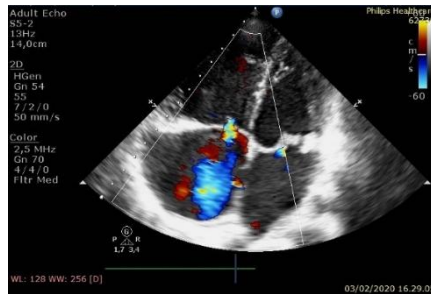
Echocardiography taken before (left side) and after (right side) PBMV. MVA planimetry was increased from 0.3 cm² (before PBMV) to 1.1 cm² (after PBMV). Tricuspid regurgitation was improved from severe (before PBMV) to mild - moderate (after PBMV).
